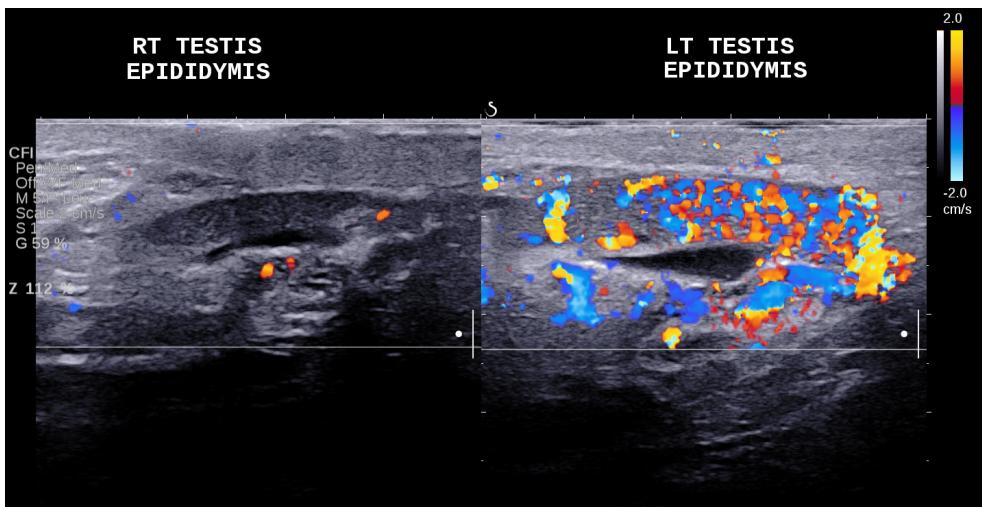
Left Epididymitis. The hallmark sonographic feature of epididymo-orchitis and epididymitis is increased color Doppler flow, see here in the left testis. Other common findings are enlargement, decreased reflectivity, and high flow/low resistance waveform on spectral Doppler.
